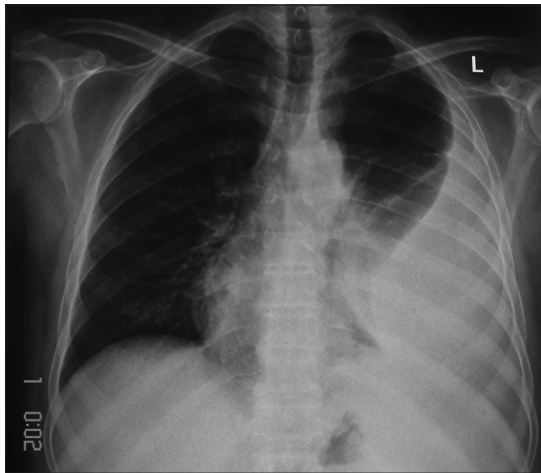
Chest X-ray showed left sided pleural effusion
